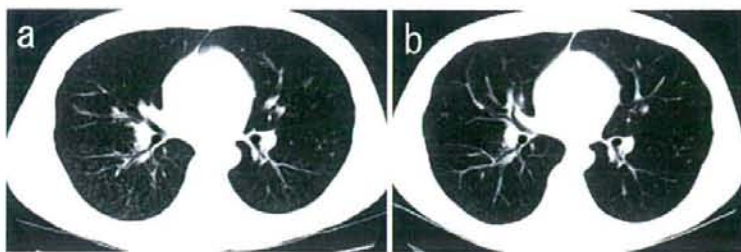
a) Chest CT on day 25 after transplantation, showing small, diffuse, centrilobular nodules, consistent with bronchiolitis. b) Chest CT on day 46, showing that the nodules have regressed.
